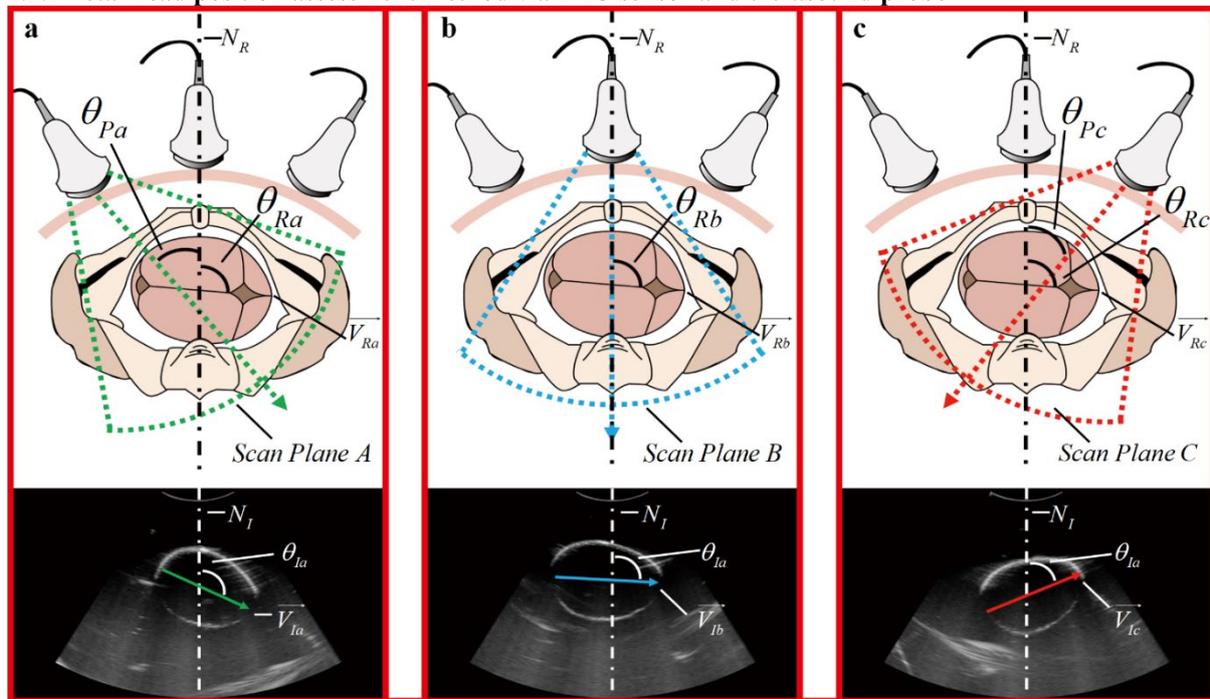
Description of method for measuring the fetal head position via ultrasonic probe and IMU sensor. (a)Place the probe at the left side of the abdomen will get Scan Plane A. (b)Place the probe at the middle the abdomen to get referenced attitude. (c)Place the probe at the right side of the abdomen will get Scan Plane C.
